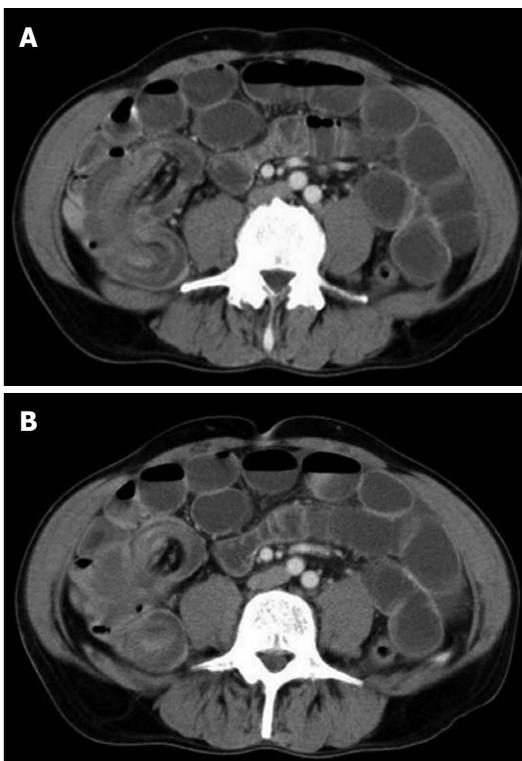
Computed tomography scan of the abdomen without oral contrast. Notice the characteristics of the mesentery - a fatty density with blood vessels. A: A longitudinal cut view of the intussusception shows the "sausage" shape; B: "Target" or "Crescent-in donut" is seen on the cross-sectional views of the intussusception.
